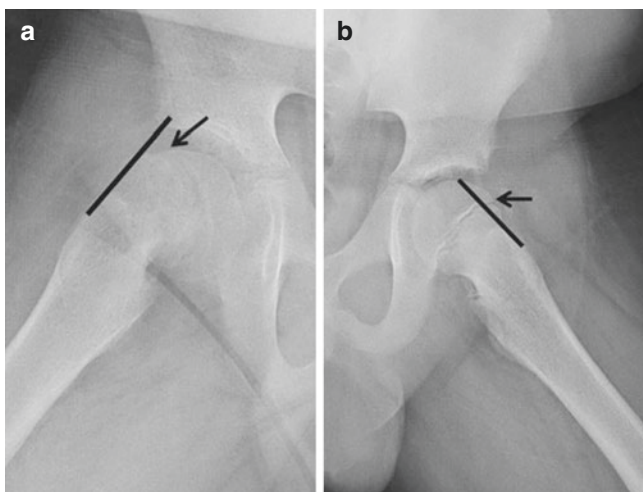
A 13-year-old boy with right hip and knee pain of 2 weeks duration. Lateral radiographs of both hips are presented in this figure. The Klein line (the black line) is drawn along the anterior femoral neck. Normally (left), the Klein line should intersect part of the epiphysis of the proximal femur (an arrow is pointing to the anterior edge of the epiphysis). Right (slipped capital femoral epiphysis; SCFE), the Klein line does not intersect any part of the epiphysis
